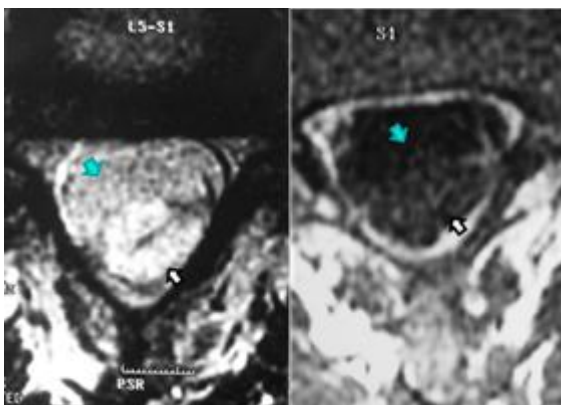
MRI of congenital dermal sinus – axial image at L₅ – S₁ level (↔) tumor; (↗) cystic formation
